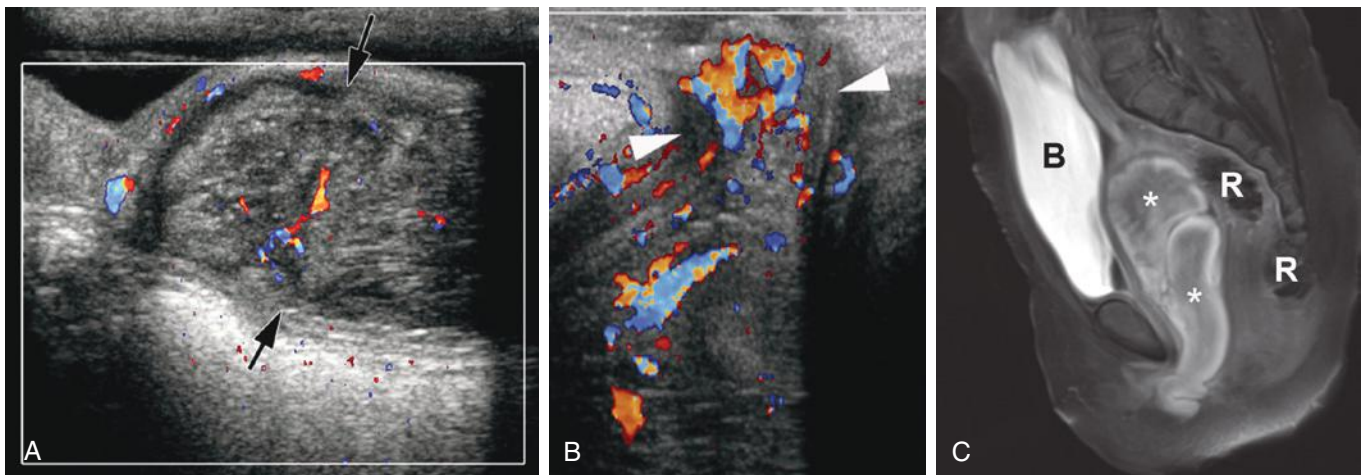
Vaginal rhabdomyosarcoma in a 16-month-old girl. A, Sagittal color Doppler ultrasound image of the pelvis shows a solid mass with vascularity filling the vaginal lumen (*between arrows*). B, Sagittal transperineal color Doppler ultrasound image demonstrates protrusion of the mass through the introitus (*between arrowheads*). C, Sagittal, intravenous contrast-enhanced, fat-suppressed, T1-weighted magnetic resonance image of the pelvis depicts the lobulated solid mass (*asterisks*) between the bladder (B) and rectum (R).
